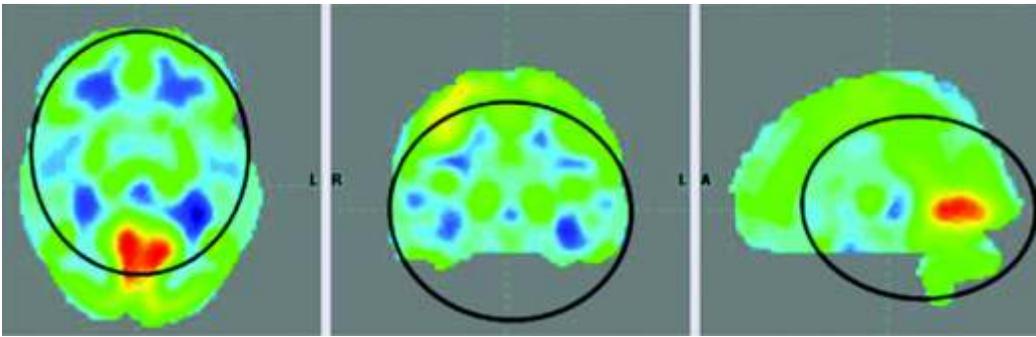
PET-CT scan before cellular transplantation showing hypometabolism highlighted in blue and black colour in the regions of mesial temporal lobes, amygdala, hippocampus, cingulate regions and cerebellum
